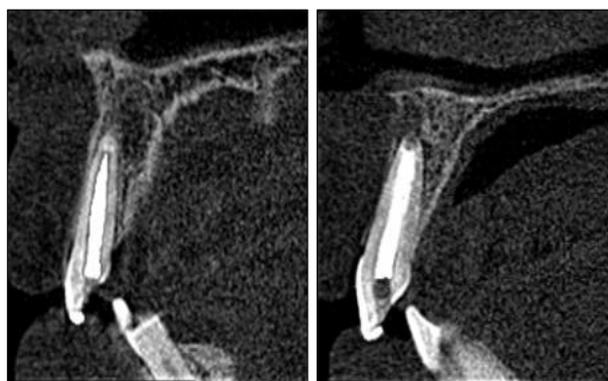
CBCT Sagittal view lateral incisor
